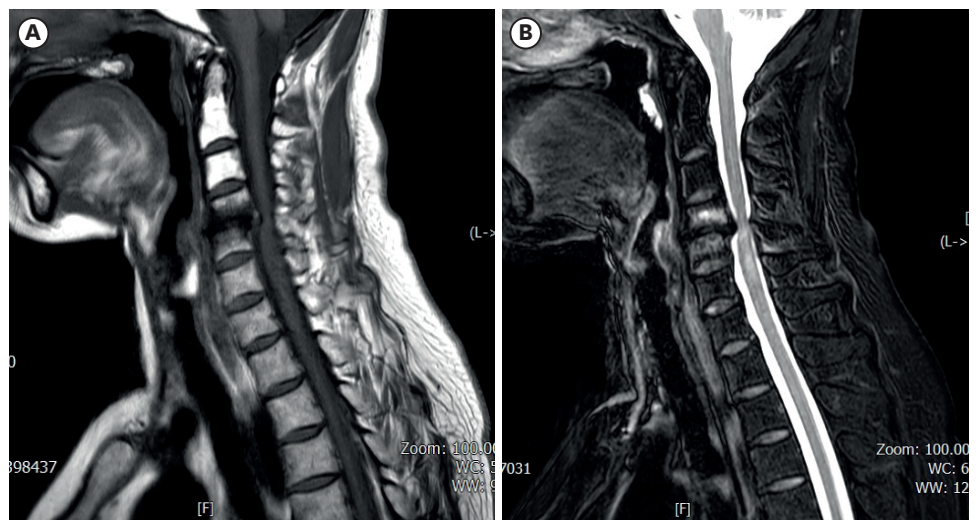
MRI of the cervical spine showing T1 low- and T2 high-signal Modic type I C4/5 endplate change and central canal stenosis at C4/5 with signal change of the cervical spinal cord. (A) T1- and (B) T2-weighted MRI. MRI: magnetic resonance imaging, C4: cervical vertebra 4, C5: cervical vertebra 5.
